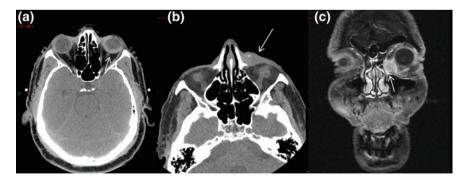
a Breast cancer metastases. Axial non-contrast CT for radiation planning with abnormal thickening of the choroid (*arrow*). b, c SCC of the skin. Axial non-contrast CT showing skin thickening extending to the nasal bone and pre-septal soft tissues (*arrow*). Coronal T1 fat-suppressed post-contrast images demonstrate lesion that abuts the anterior globe and may involve insertion tendon of medial rectus muscle (*arrow*)
